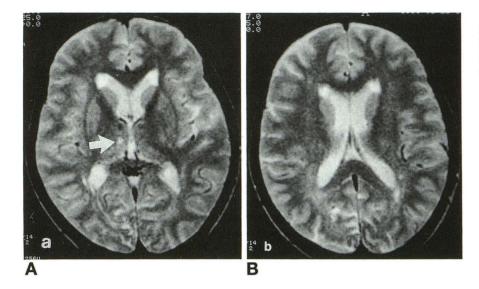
Case 4. T2-weighted axial images showing mild periventricular hyperintensity. Note the presence of a high-signal abnormality in the right thalamus (*A, arrow*).
